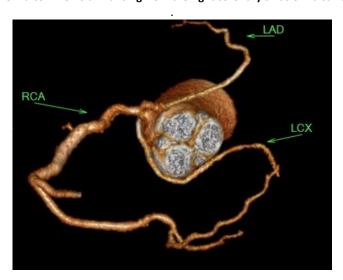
CT shows the inter arterial course of the left anterior descending artery between the aorta and the pulmonary trunk
